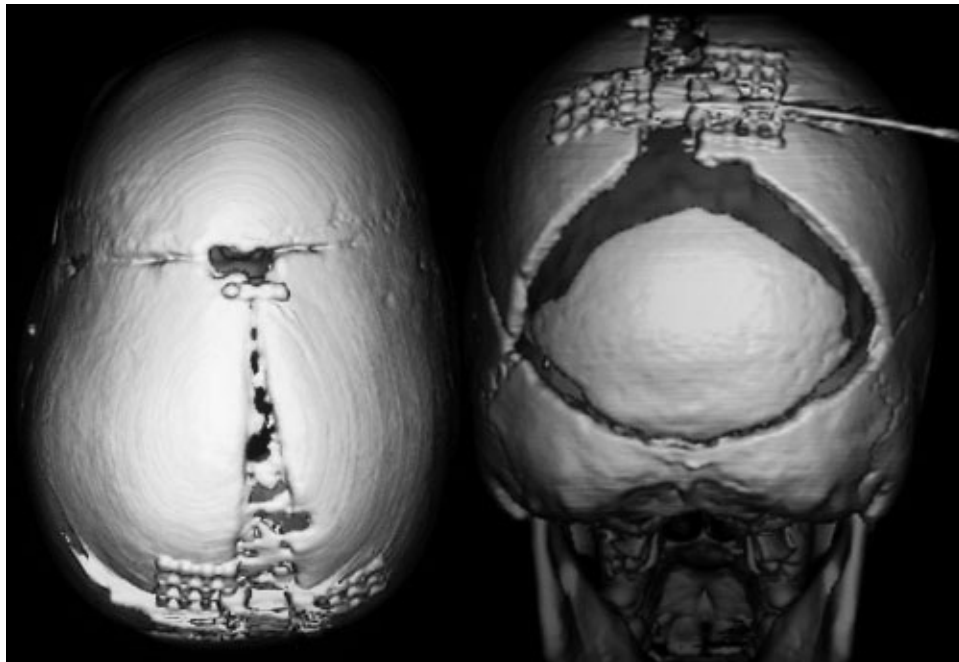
• CT scan at full distraction after consolidation.
